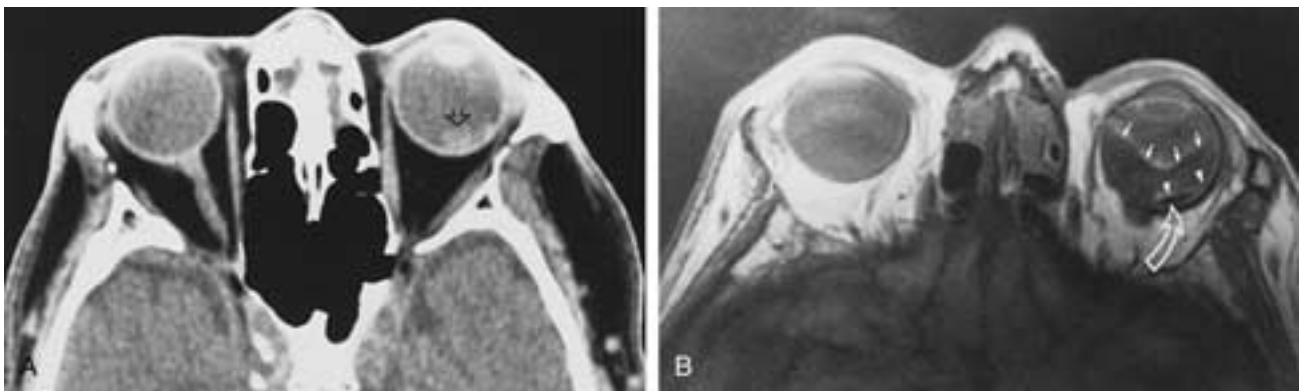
Senile macular degeneration associated with complications. A, Axial CT scan shows a mass (*arrow*) and a dependent image probably caused by effusion in the subretinal space. B, Axial T1-weighted MR image shows the characteristic posterior hyaloid detachment (*arrows*). Unlike retinal detachment, a detached posterior hyaloid membrane does not extend toward the optic disc. Note the detached retina (*arrowheads*) and the hypointense image (*curved arrow*) related to scar tissue in the subretinal and retinal regions. Surgery confirmed these findings. Notice that information obtained by MR imaging is far superior to that obtained by CT.
